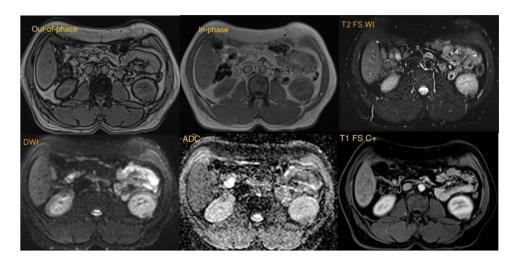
Multi-axial contrast enhanced MRI of the abdomen demonstrates focal-well defined soft tissue lesion in the lower aspect of the left kidney, showing low signal T1 and T2 WI, with faint restricted diffusion and heterogenous enhancement on post contrast images.
